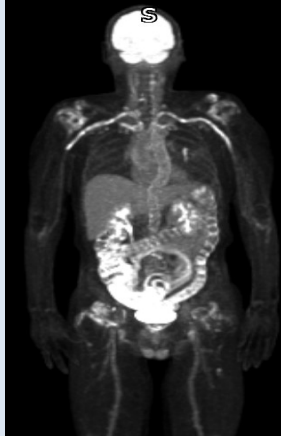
FDG-PET/CT showing widespread vascular high FDG uptake
